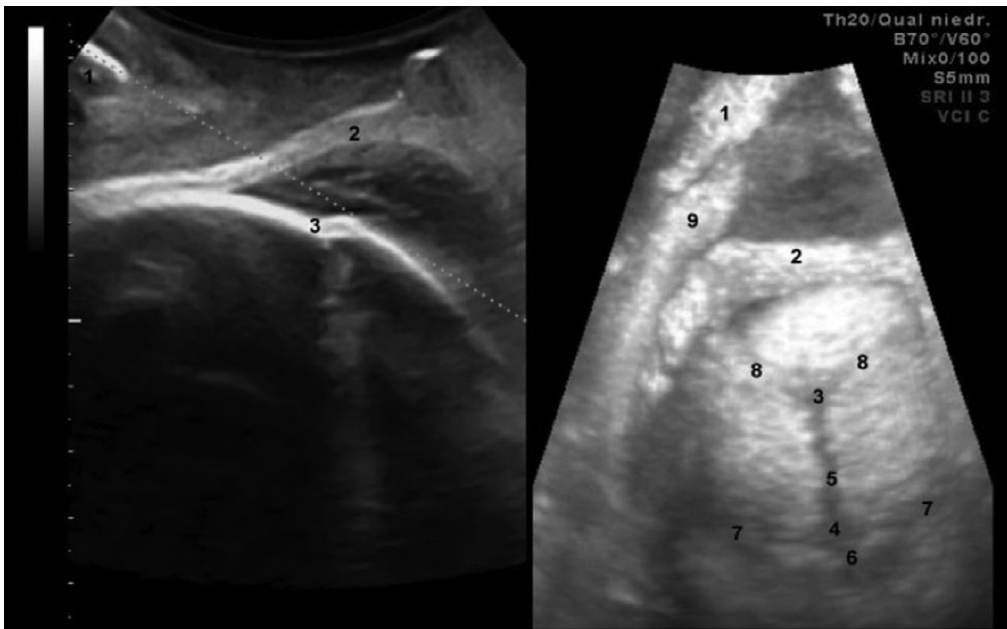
Sagittal view of the maternal pelvic outlet in the second stage of labour on translabial 2D and 3D ultrasound. The 2D image (left) demonstrates the symphysis (1), the caput succedaneum with hyperechogenic skin and hypoechogenic subcutaneous edema (2) and the fetal head with moulding of the bones (3) at the posterior fontanelle. The tangent on the inferior margin of the pubic symphysis and the fetal skull can be seen as a dotted line from the symphysis to the vertex of the head. The 3D image (right) shows the fetal head after completed internal rotation: the leading triangular posterior fontanelle (3), the quadrangular anterior fontanelle (4), and the sagittal (5), metopic (6), coronary (7) and lambdoid (8) sutures, the fetal skin (2), the birth canal (9) and parts of the pubic arch (1) are visible (with permission from Fuchs *et al.*³⁴).
